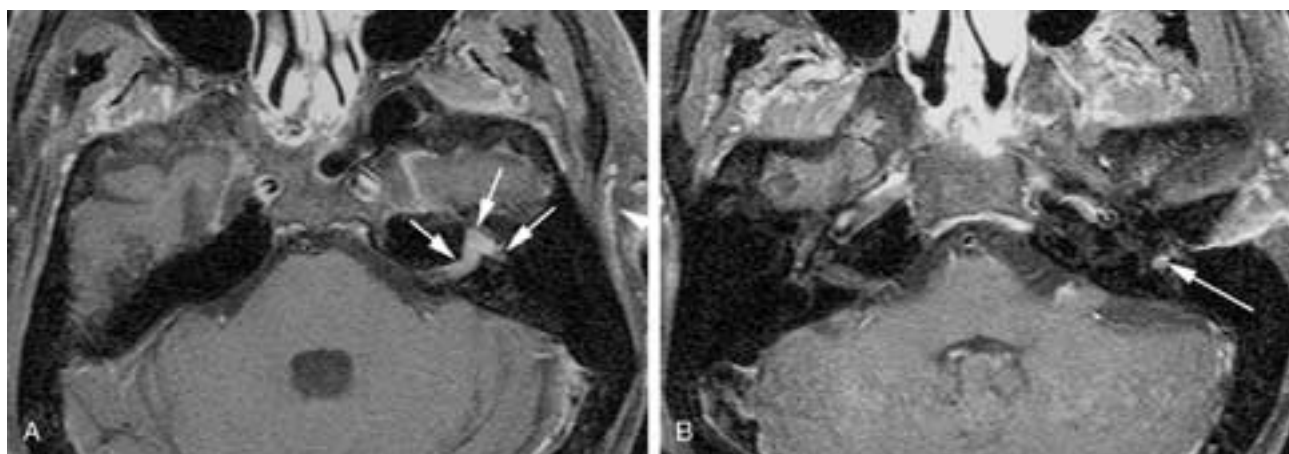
MR imaging of perineural spread from adenoid cystic cancer of the parotid gland (not shown). A, Postgadolinium T1-weighted MR image with fat suppression. There is enlargement of the anterior tympanic segment (*lateral arrow*) and the geniculate turn (*middle arrow*), as well as the labyrinthine segment of the FNC. There is an enhancing mass (*medial arrow*) extending into the IAC. B, Caudal slice shows the enlarged, enhancing facial nerve (*arrow*) at the region of the pyramidal turn. (Courtesy of Dr. Peter Som.)
